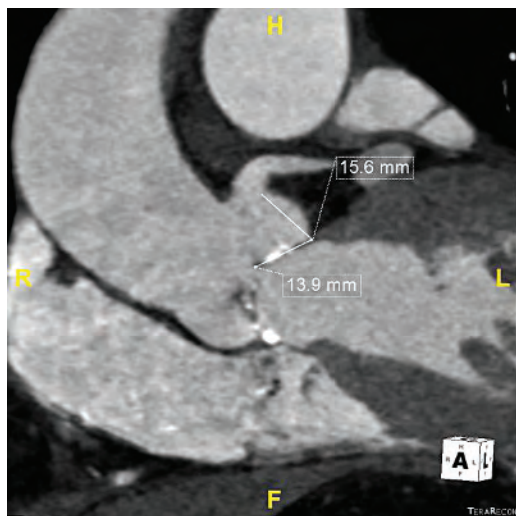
Computed tomography assessment of left main ostial height and left coronary cusp leaflet length.
